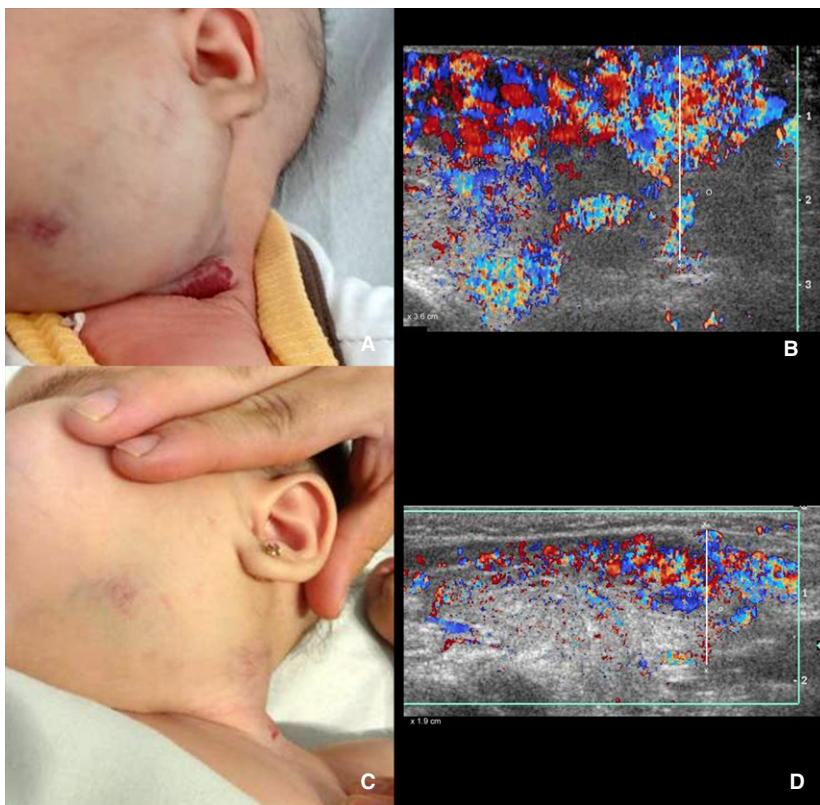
Hemangioma on the face and neck. (A) Clinical evaluation before treatment. (B) Color Doppler ultrasound (CDU) evaluation before treatment demonstrates diffuse lesional hypervascularity and involvement of the left parotid gland. (C) Clinical follow-up at 3 months. (D) CDU follow-up at 3 months shows decreased hypervascularity. Thickness (x) measurements and the parotid gland (o) are shown in B and D (CDU transverse axes).
